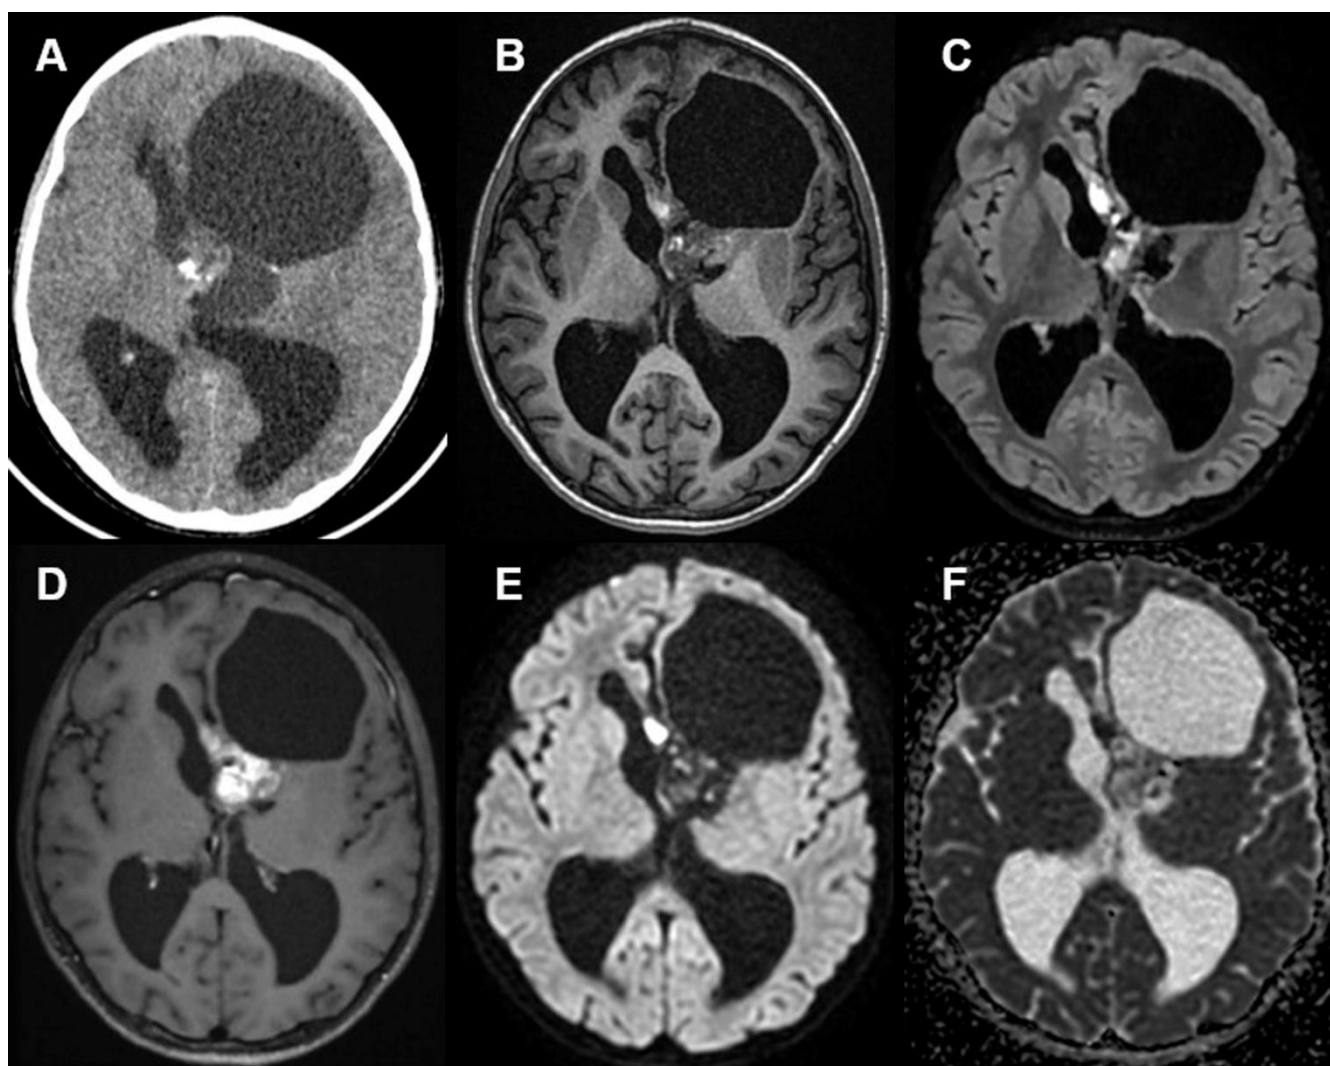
Radiological features: Axial unenhanced CT(A), T1-weighted (B), FLAIR (C), post-contrast T1-weighted (D), diffusion (E), and apparent diffusion coefficient (ADC) map (F) images of the patient, showing a large mass within the left lateral ventricle having solid and cystic content (MRI performed after cyst aspiration). CT showed the solid component to have intermediate density and calcification, intense contrast enhancement, and no diffusion restriction.
